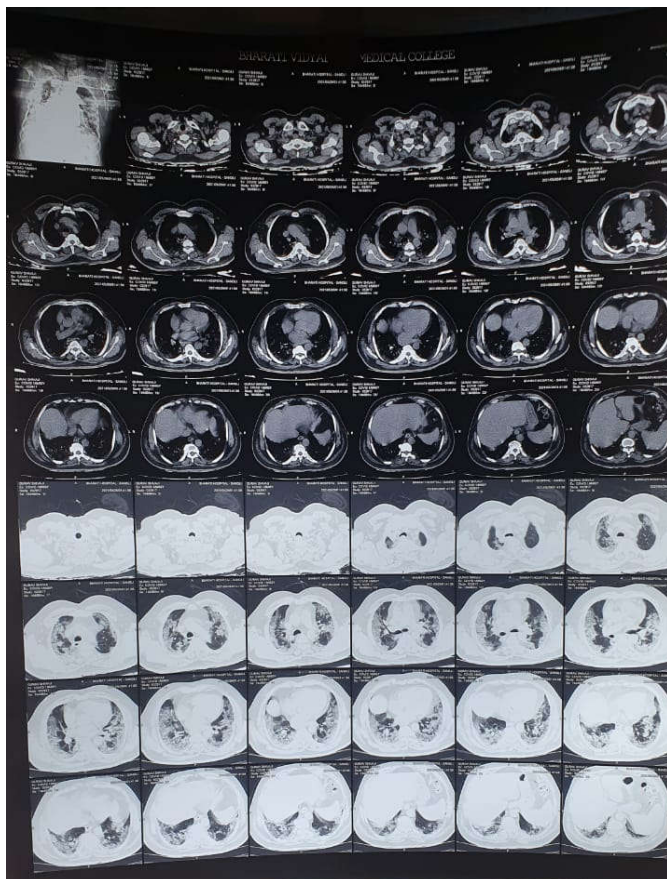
CT showing diffuse lung involvement
